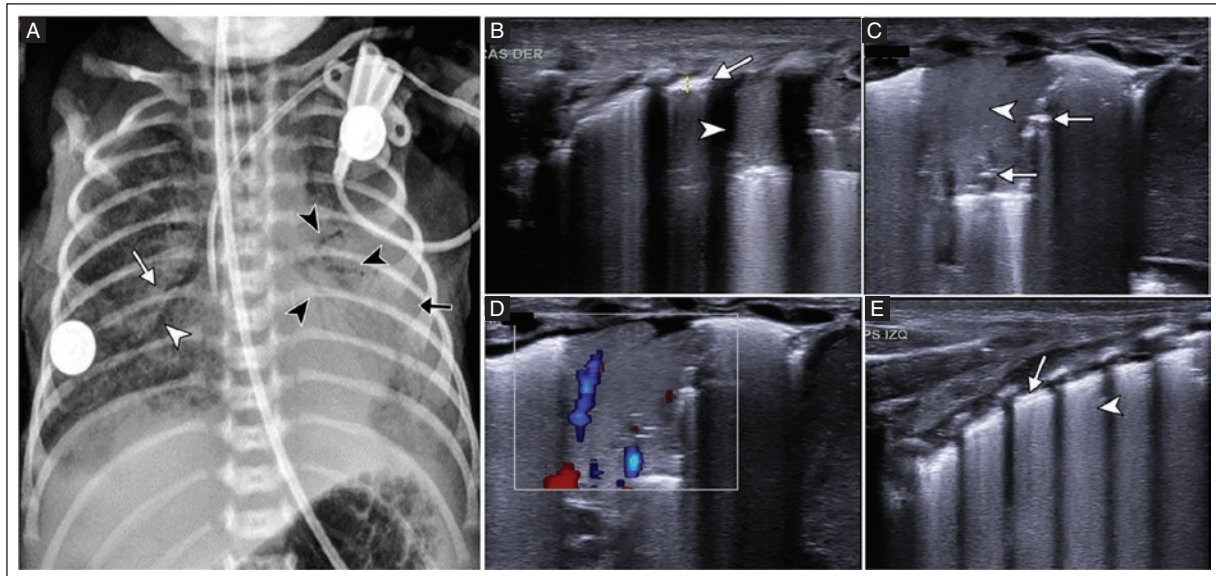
Full-term neonate at 37 weeks gestation with 5 days of extrauterine life with an NRD and fever. A: AP chest X-ray shows an area of consolidation in the right middle lobe (white arrow) with air bronchograms (white arrowhead). There are more areas of consolidation in the lingula and the posterior segment of the left lower lobe (black arrowheads) with air bronchograms (black arrowhead). A central venous catheter with a tip at the cavoatrial junction and an orogastric tube and electrodes can be seen. B: lung POCUS of the right anterior upper quadrant with pleural line thickening (white arrow) next to the consolidation area (white arrowhead). C: lung POCUS of the left hemithorax in the lateral quadrant with a focal subpleural parenchymal consolidation (white arrowhead) with air bronchograms (white arrows). Hepatization of the lung parenchyma was noted. D: lung POCUS, with color Doppler showing vascular flow in the same area of consolidation. E: lung POCUS of the left posterior upper quadrant showing pleural line thickening (white arrow) and increased B-lines corresponding to a "white lung pattern" (white arrowhead). The diagnosis was pneumonia on the chest X-ray and shortened lung POCUS.
